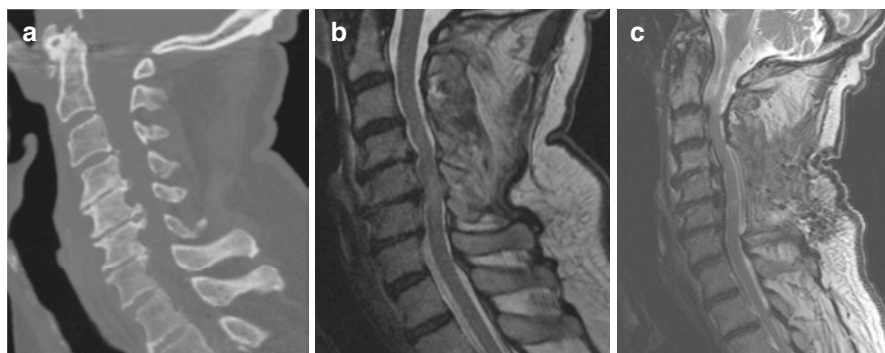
Radiographic findings in a 91-year-old male patient presenting with dense central cord syndrome. (a) Sagittal CT cervical demonstrates C4-C5 and C5-C6 disc/osteophyte complexes, but no bony fracture or facet dislocation. (b) Sagittal MRI cervical spine demonstrates T2 cord signal at C4-C5 and diffusely at C5-C6 consistent with spinal cord edema. (c) Sagittal MRI 1 month following C4-C6 laminectomy without instrumentation. MRI revealing posterior decompression of cervical cord with consolidated intramedullary T2 cord signal
